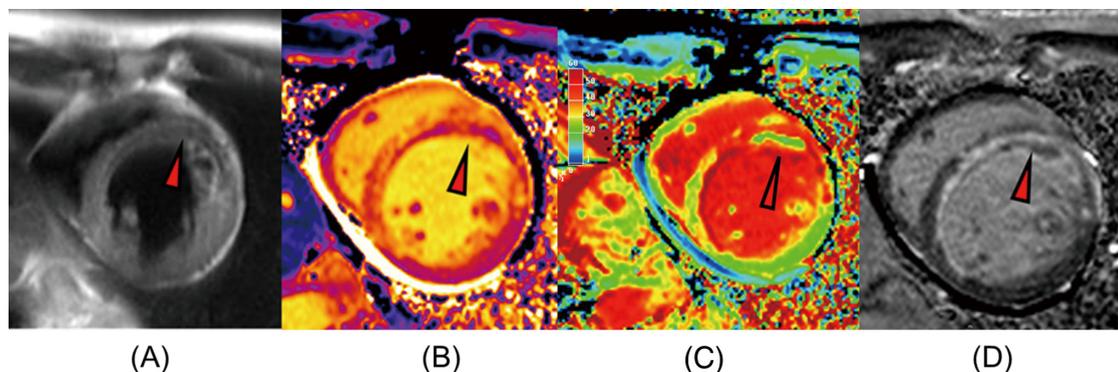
Representative CMR images of T1 hypointense infarct core in patients with reperfused AMI. (A) T2-weighted image: microvascular injury appears as a hypointense band at the anterior endomyocardium (arrowhead), but the border separating the infarcted area and normal myocardium is unclear. (B) Native T1 mapping: T1 hypointense infarct core is clearly visualized within the infarcted lesion (arrowhead). Native T1 mapping acquired using non-contrast imaging calculated by the modified Look-Locker inversion recovery protocol. (C) Extracellular volume mapping: microvascular injury appears as a hypointense area within the anterior myocardium (arrowhead). Image reconstructed using native and contrast-enhanced T1 mapping adjusted for the hematocrit. (D) Late gadolinium enhancement image: microvascular obstruction is detected as a low-intensity area within the enhanced myocardial tissue (arrowhead). AMI, acute myocardial infarction; CMR, cardiac magnetic resonance imaging.
